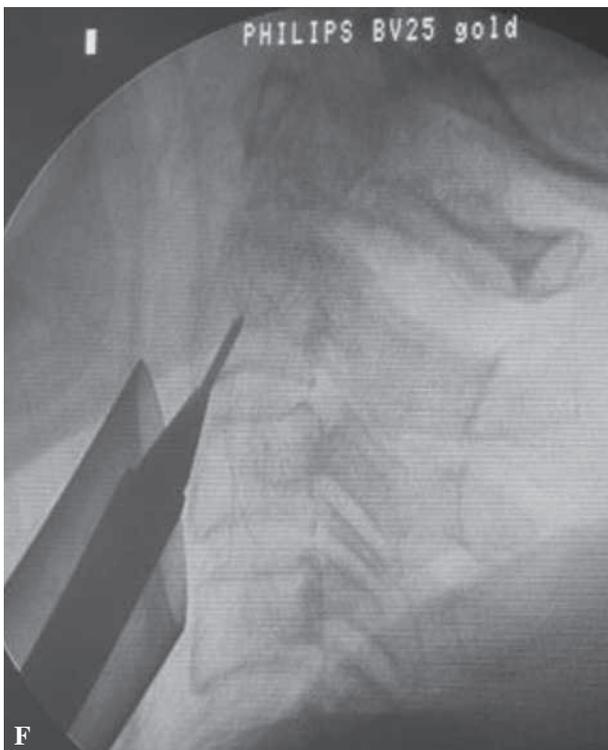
Anteroposterior radiographs of a 46-year old man with type II odontoid fracture (A). The preoperative MRI showed type II odontoid fracture (B). Working channel was established with percutaneous approach (C, D).
